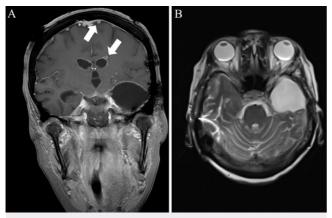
Hyperintense T1 intensity of the DC on coronal contrastenhanced MRI (A) and iso- to slightly hypointense T2 intensity of the DC n axial MRI 51 days after admission (B). Leptomeningeal enhancement is indicated by *white arrows*.
